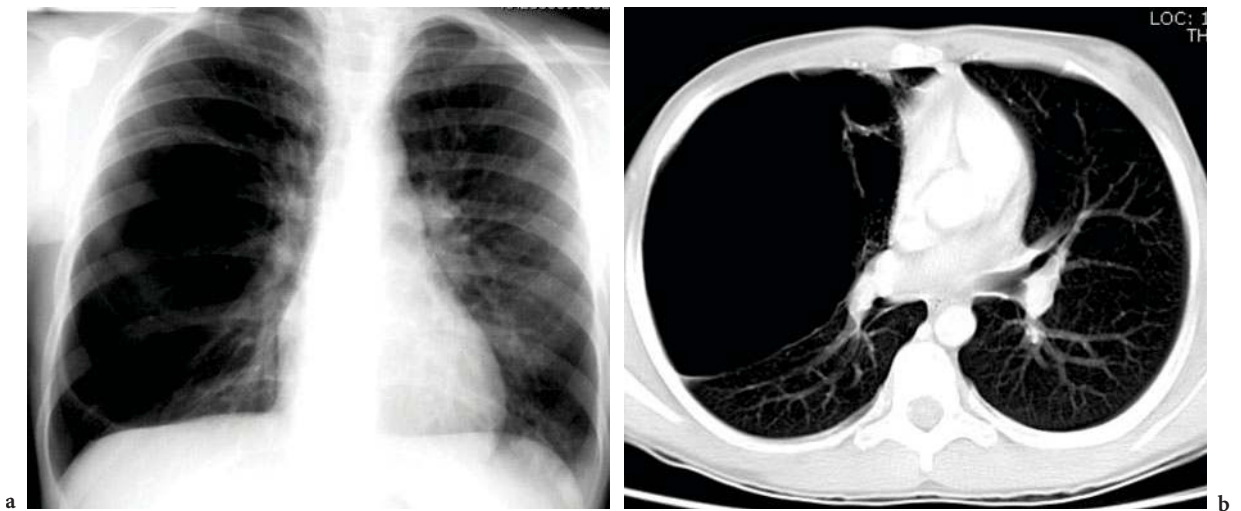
Late-discovery right CPAM in an asymptomatic 11-year-old female without past medical history. a Chest X-ray. b CT
